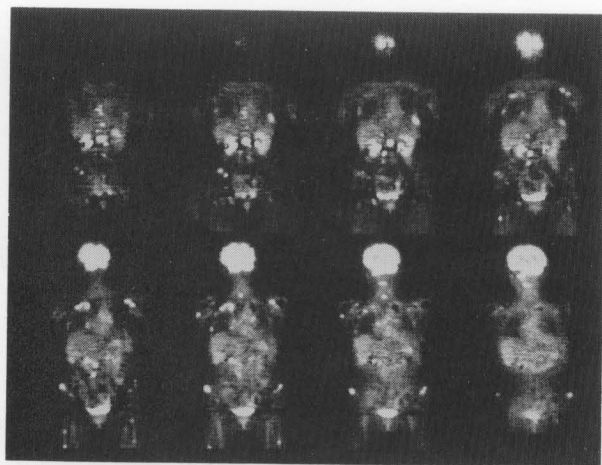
Coronal sections of 2D ^{18}F FDG whole-body scan of cervical uterine cancer patient depict multiple bone metastases.
